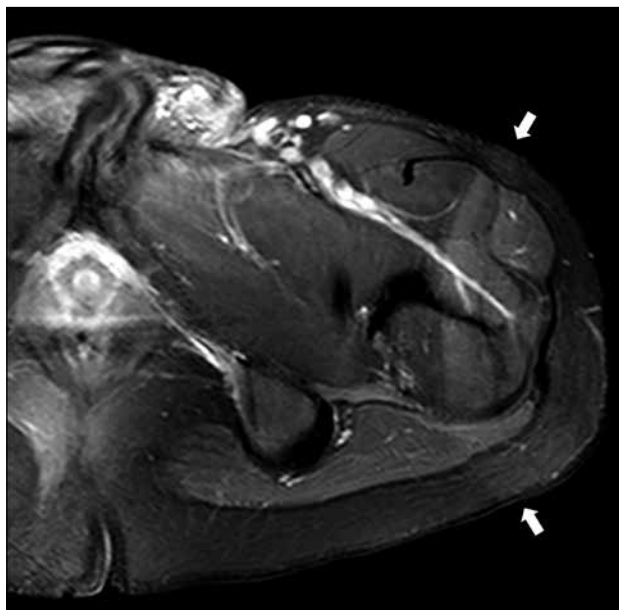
Axial T1-weighted post-contrast image of the left hip showing aliasing artifact at the lateral aspect of left hip, with a rim of signal hyperintensity overlapping the anatomy (white arrows).
